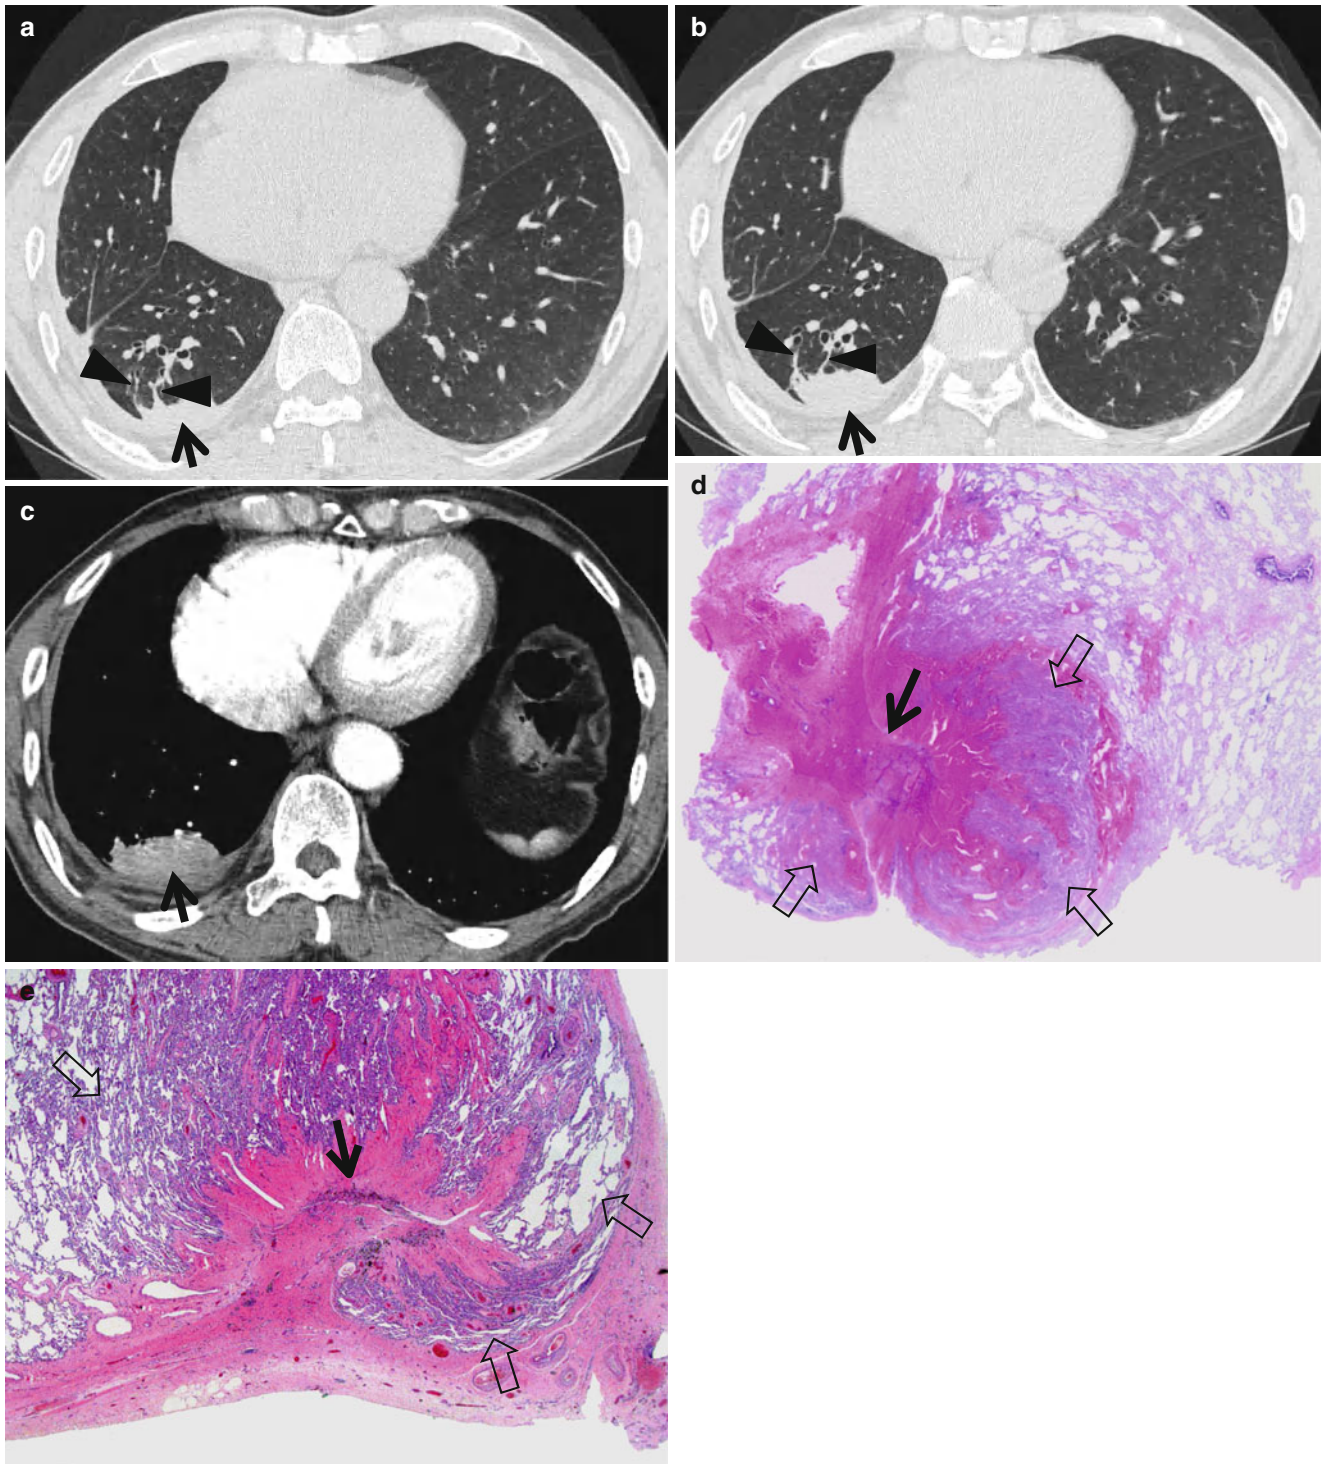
Rounded atelectasis in a 66-year-old man complaining of shortness of breath and cough. (a, b) Consecutive thin-section (1.5-mm section thickness) CT scans obtained at ventricular level show the atelectatic right lower lobe (*arrows*) abutting pleura. Also note two vascular curvilinear soft tissue attenuations (*arrowheads*), extending from anterior margin of the atelectatic lung to pulmonary hilum; these two structures may help explain parachute sign (please refer to definition of comet tail sign) on chest radiograph in this particular condition (rounded atelectasis). Also note right pleural effusion and thickening, posterior to
